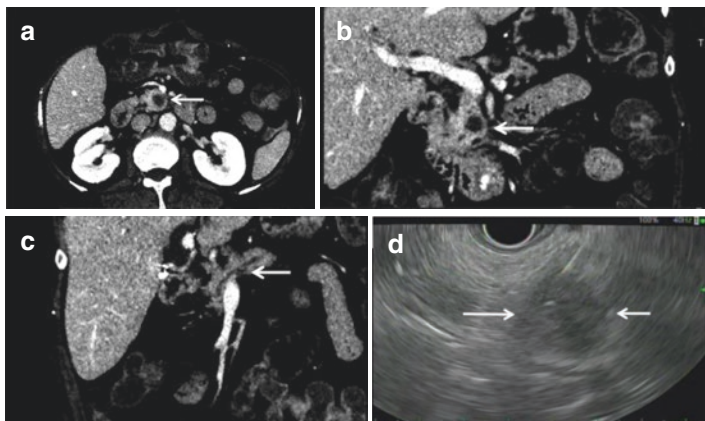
(a/b) Low radiodensity mass in the uncinate of the pancreas (arrows) visualized on cross section and coronal CT scan images. (c) Upstream pancreatic duct dilation on coronal CT scan images. (d) EUS images with a linear echoendoscope of the uncinate pancreas from second portion of the duodenal, mass visualized (arrows)
